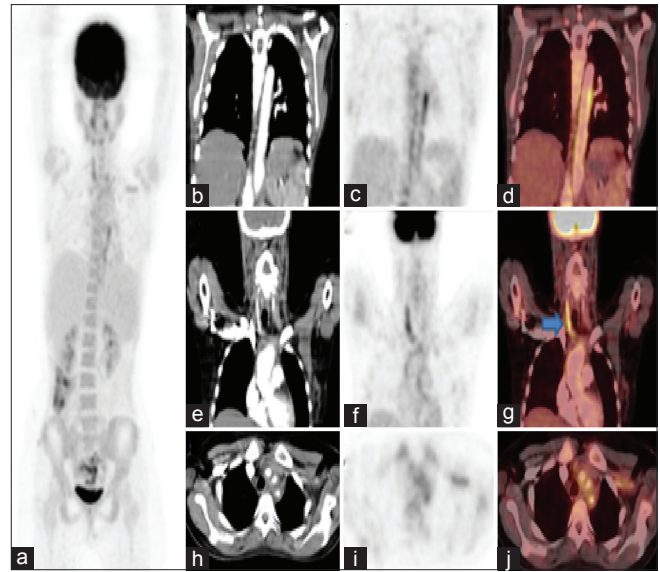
Case 2 - Maximum intensity projection image (a) showing linearly increased fluorodeoxyglucose uptake in the mediastinum and left side of the chest wall. Coronal (b-g) and axial (h-j) sections of contrast-enhanced computed tomography, positron emission tomography and fused positron emission tomography-computed tomography images showing increased fluorodeoxyglucose uptake in aortic wall with maximum standardized uptake value: 4.3, right common carotid artery maximum standardized uptake value: 3.7 and arch of aorta maximum standardized uptake value: 2.6 (liver maximum standardized uptake value: 1.8)
